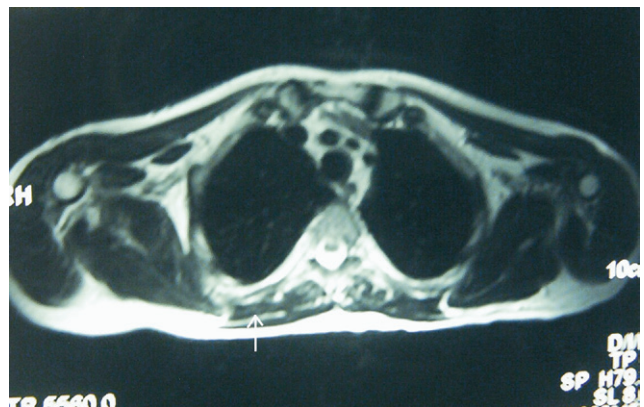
Thoracic MRI in T2-weighted axial sections. The right rhomboid muscle (white arrow) is thinner and has a pathologic signal. The right scapula is located more laterally.
